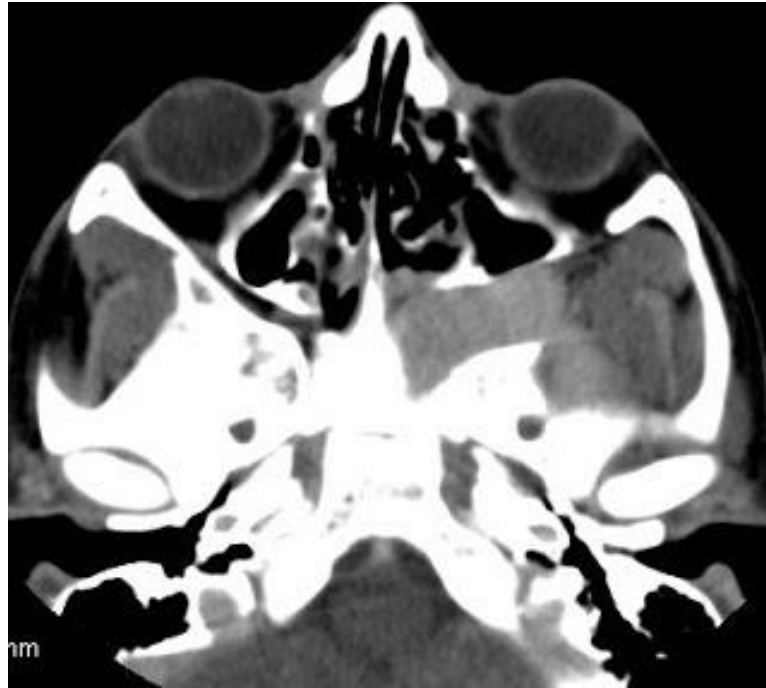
Juvenile Nasopharyngeal Angiofibroma. Axial CT scan of paranasal sinus show enhanced soft tissue lesion in roof of left side of nose involving sphenopalatine fossa extending superiorly to involving pterygopalatine fossa causing widening of it and anterior bowing of posterior wall left maxillary sinus. The lesion also involve left temporal fossa (en.wikipedia.org/wiki/Maxillary sinus disease)
